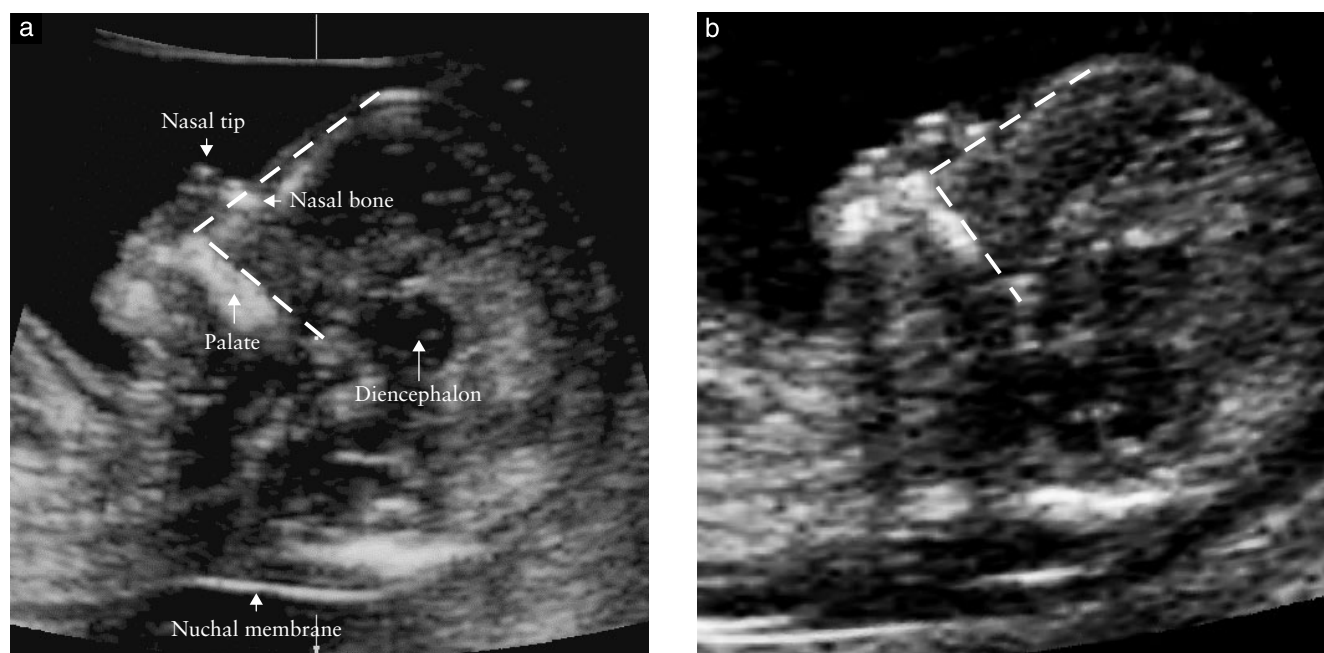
Ultrasound images showing measurement of the frontomaxillary facial angle in a chromosomally normal (a) and trisomy 21 (b) fetus. The angle is defined by a line along the upper surface of the palate and a line from the upper corner of the anterior aspect of the maxilla extending to the external surface of the frontal bone.
